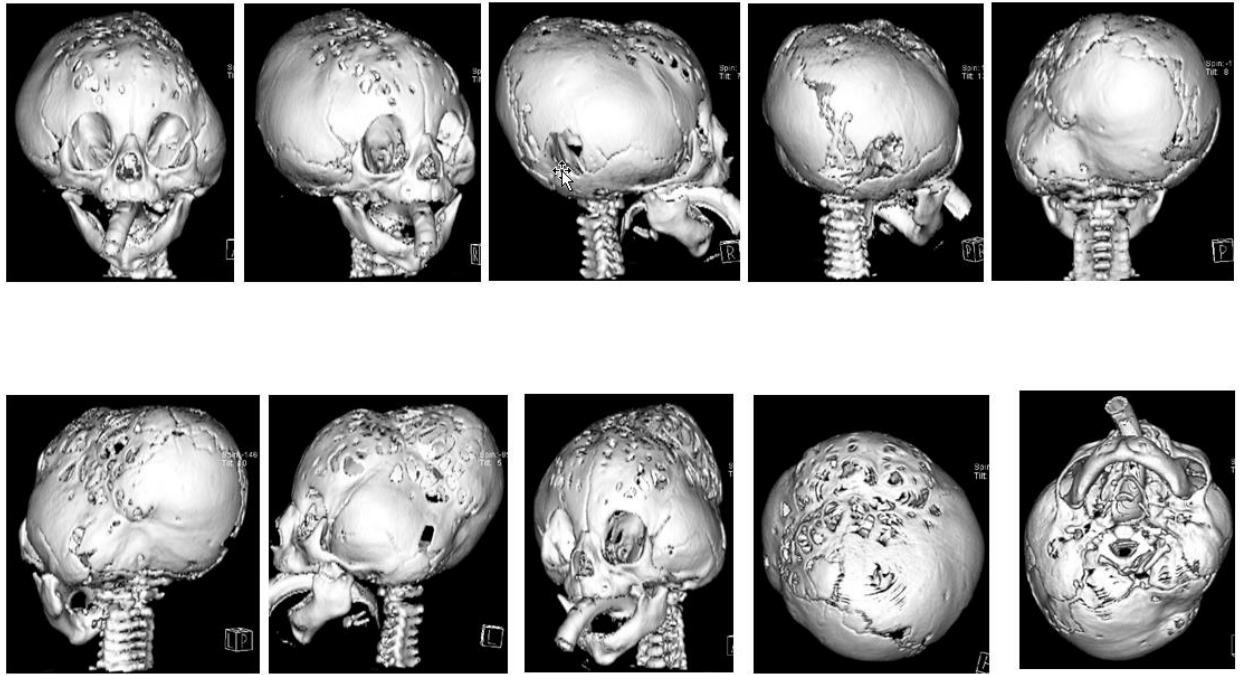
3D CT IMAGES OF V-1
